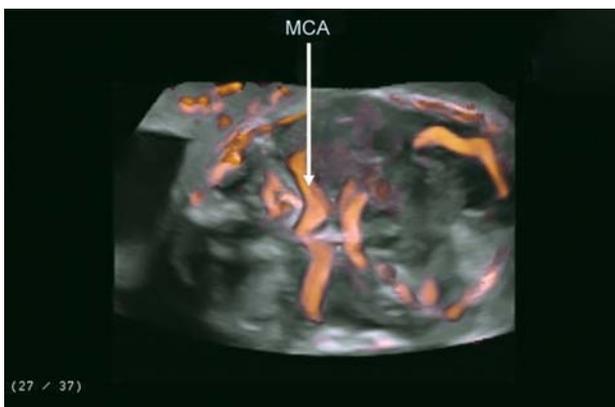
Circulus arteriosus Willisii with middle cerebral artery (MCA) 3D power Doppler
